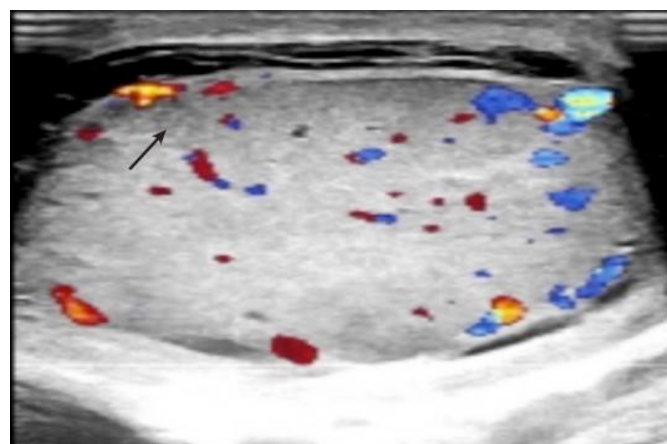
An ultrasound of the external genitalia suggests the enlargement of the right testis and epididymis, there is a small hypoechoic area inside, considered to be a microabscess (arrow).
